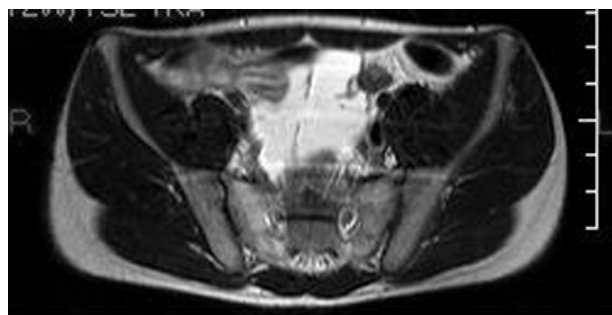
MRI scan showing the mass in contact with small bowel loops.
